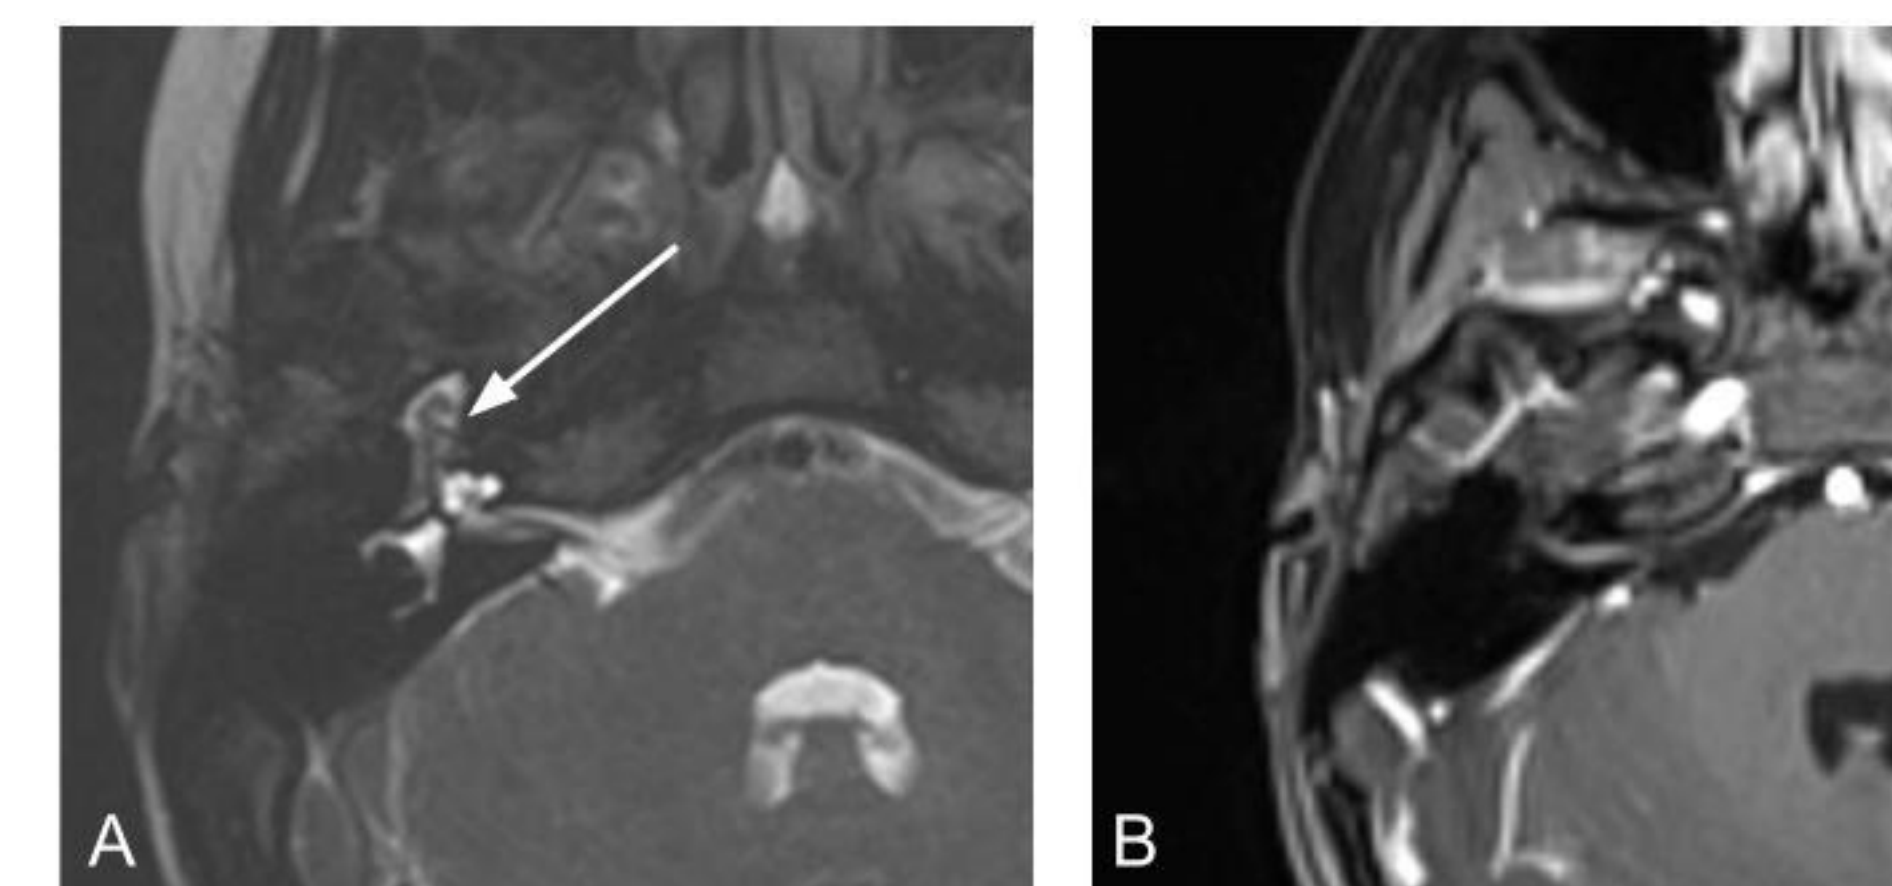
(A) Axial CISS sequence MRI of patient 2 demonstrating the lesion which is mostly hyperintense (arrow). (B) Axial post-gad fat-sat T1 MRI of showing lesion isointensity and some edema of the facial nerve in the IAC.
